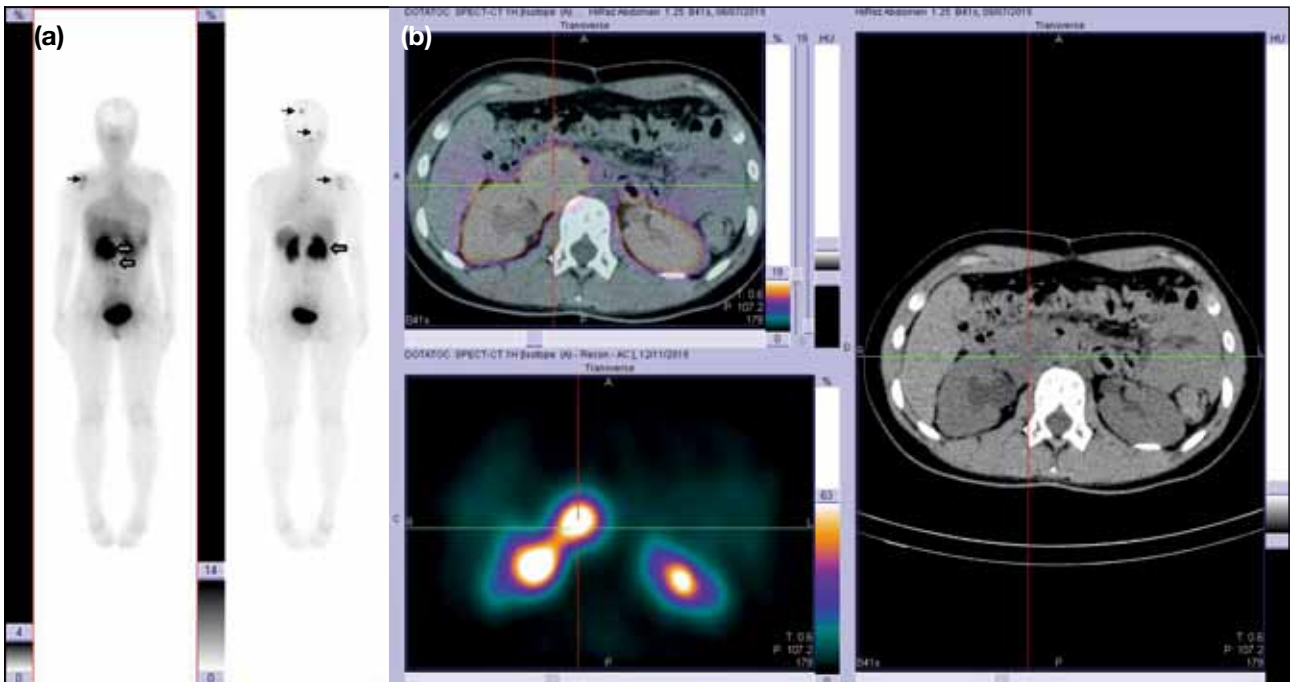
In a patient with neuroendocrine tumour: (a) ¹¹¹In-DOTATOC whole-body planar scanning and (b) transaxial single-photon emission computed tomography–computed tomography at the renal pelvis level showing the retroperitoneal metastases (block arrows and cross-hairs) and bone metastases (arrows).
